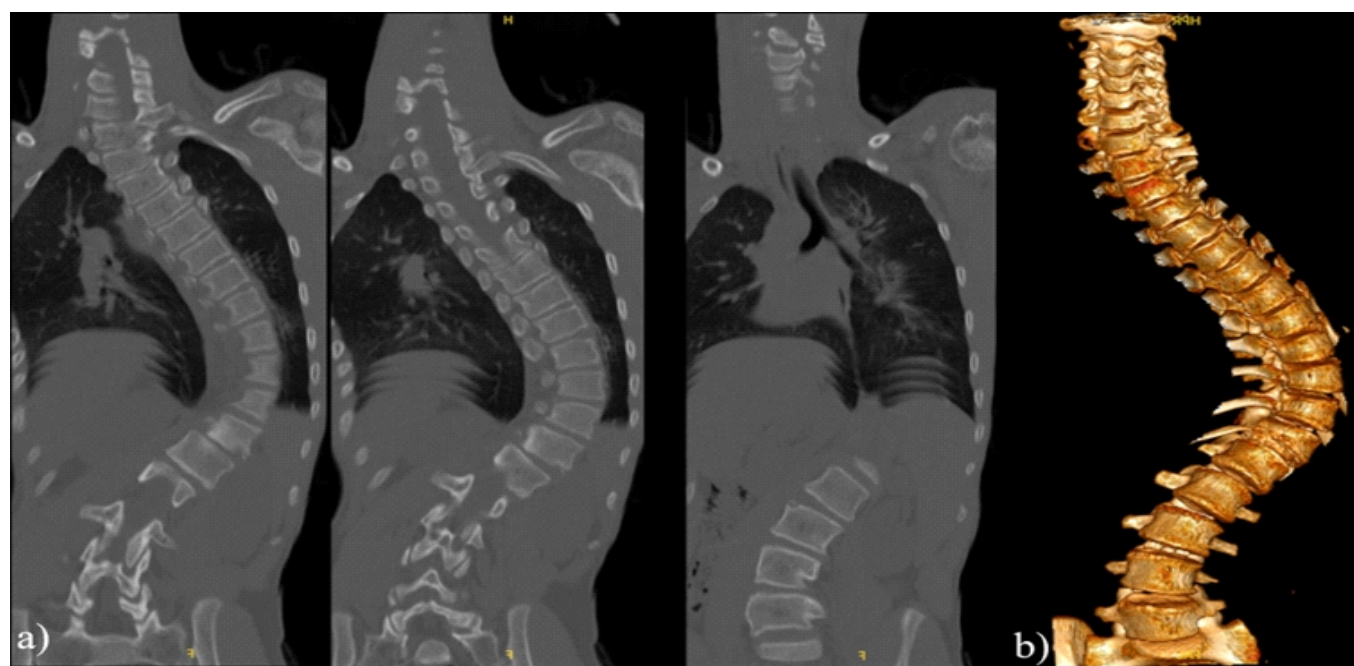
Coronal and three-dimensional computed tomography (CT) assessment of the spinal deformity. (a) Coronal-plane CT demonstrating a single C-shaped thoracolumbar curve with its apex at T9-T10. (b) Three-dimensional CT reconstruction facilitates multiplanar characterization of the deformity. Thin-slice CT additionally demonstrates a posterior fusion defect at S1, with no other vertebral segmentation or fusion anomalies and no osseous septum within the spinal canal.
